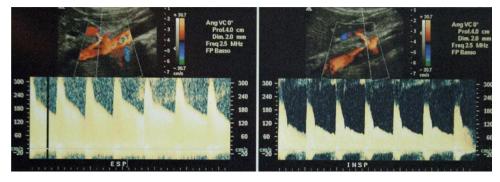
Preoperative Eco-color-doppler of aorta and celiac trunk preoperative during inspiration and expiration.
